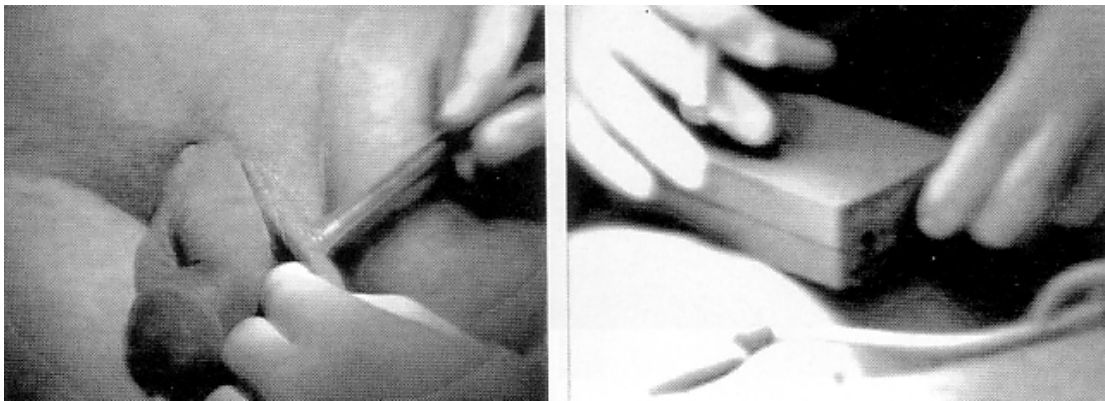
Intraoperative Doppler
